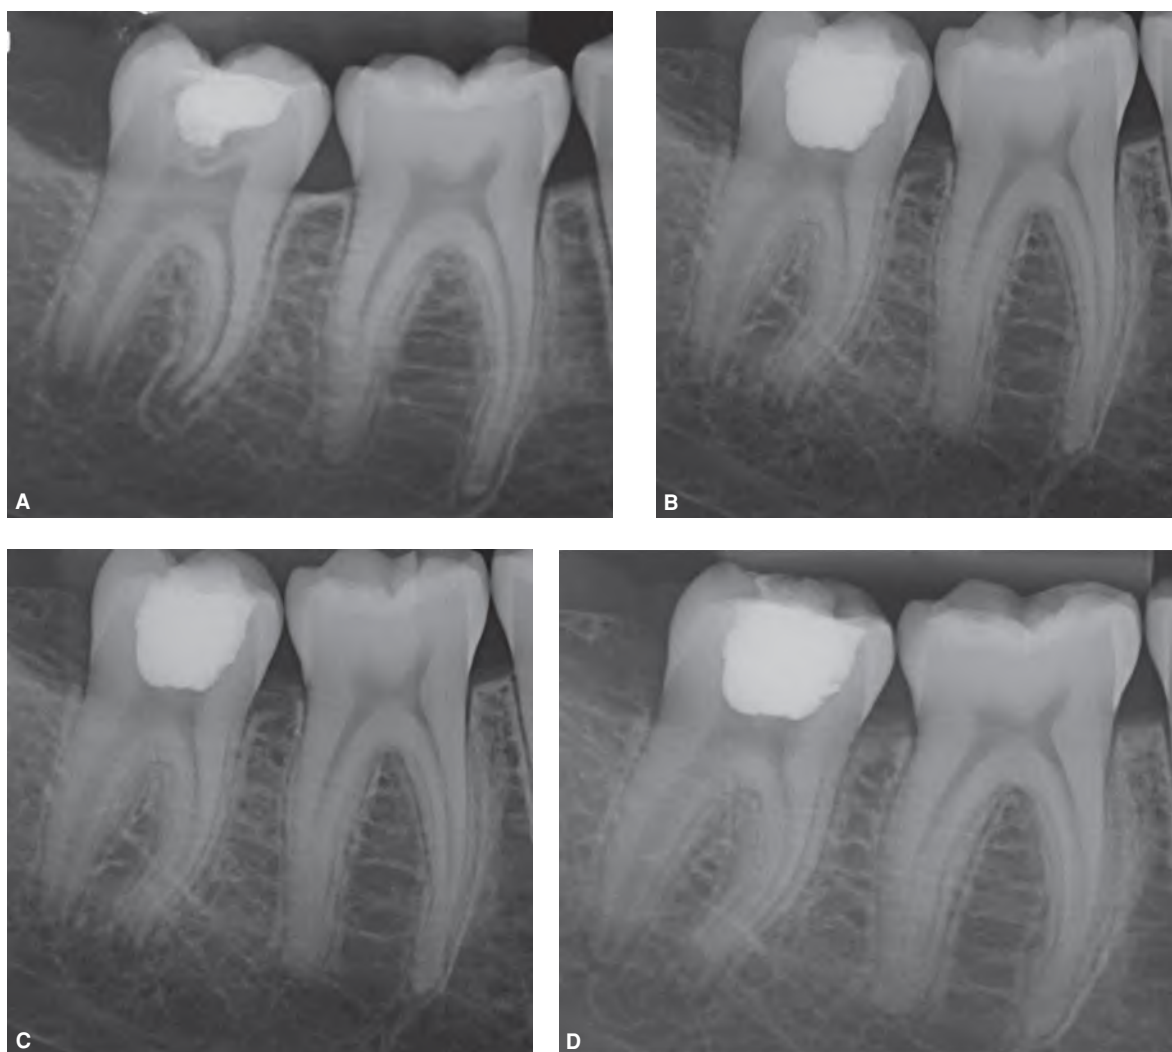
Indirect pulp cap in a mandibular right second molar in a 13-year-old male patient. A. First step indirect pulp cap (stepwise excavation) after treatment interval of four months with retained arrested deep layer of carious dentin in innerpulpal quarter. B. Post-operative radiograph after completed step-wise excavation (two-step indirect pulp cap). C. One-year radiographic review. D. Two-year follow-up with completed apexogenesis, pulp sensibility present and well-defined lamina dura evident. (© Dr. Lars Bjørndal 2015. All rights reserved.)
